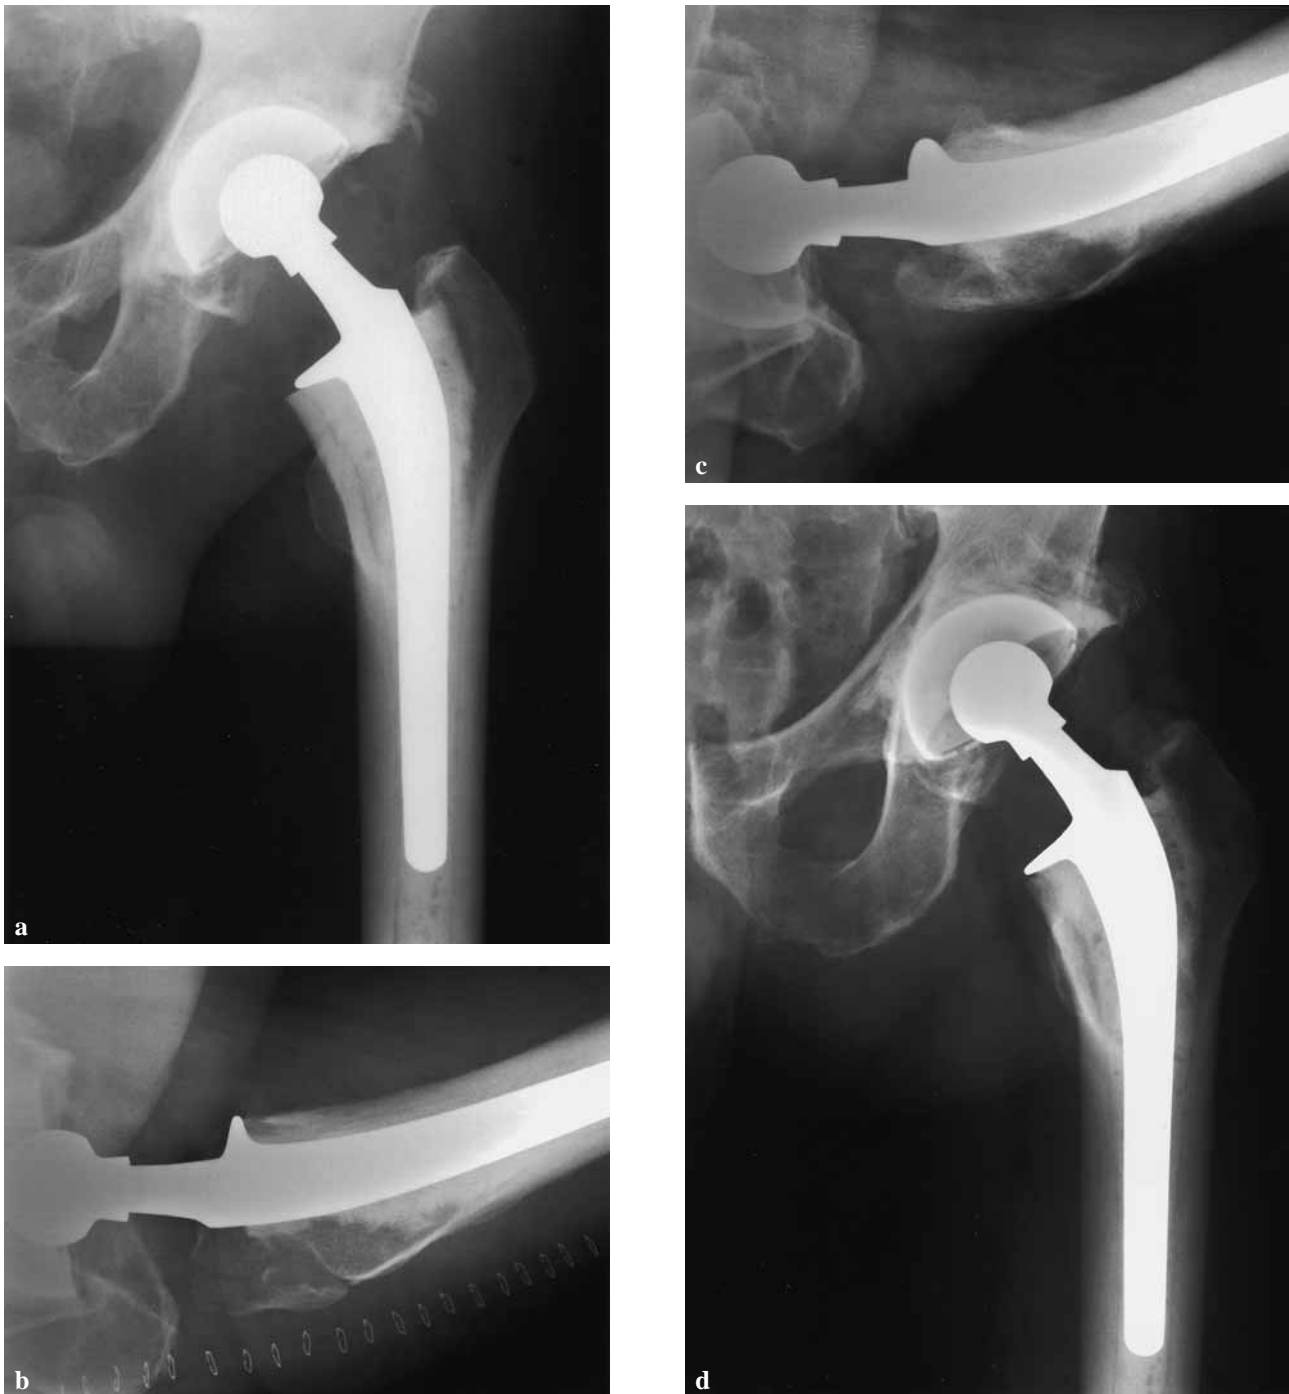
a, b*) Anteroposterior and lateral views obtained immediately following hip arthroplasty performed through the posterior approach using a posterior trochanteric osteotomy. The osteotomy site is clearly visible on the lateral view. *c, d*) Radiographs of the same patient 2 years later showing union of the trochanteric osteotomy fragment but some degree of proximal migration (see text).
